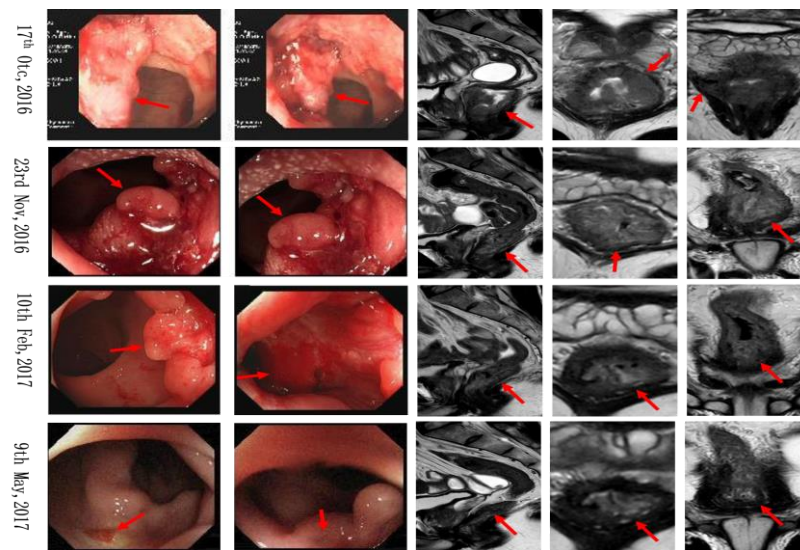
Tumor changes during treatment by colonoscopy and MRI examination
